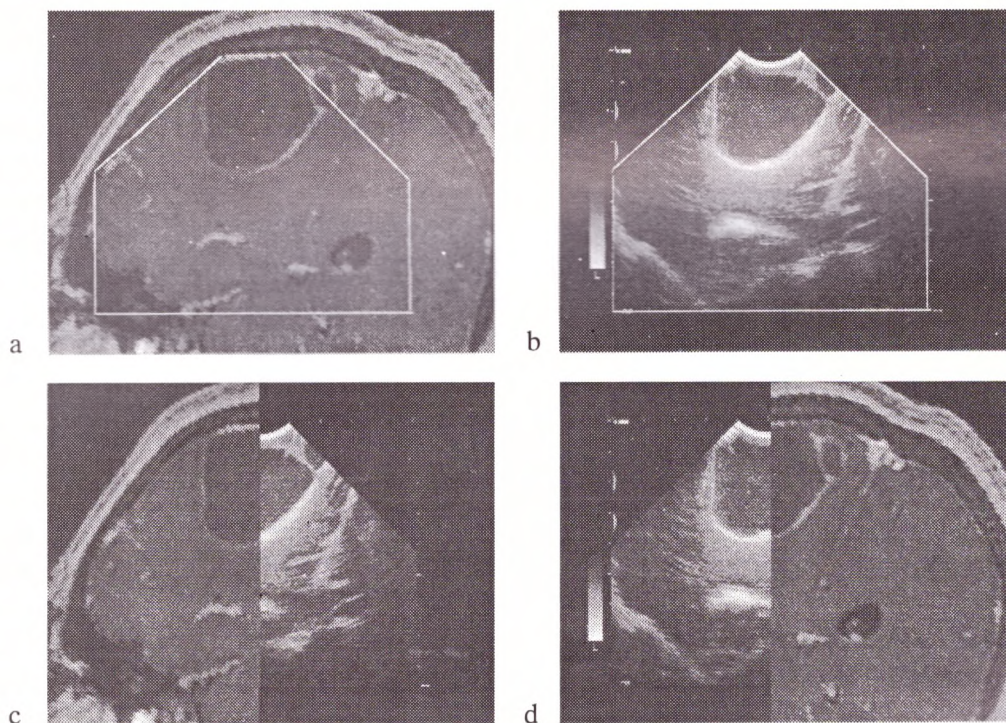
Corresponding intraoperative ultrasound (b, c, d) and reformatted MRI (a, c, d) images in a case of resection of a cystic metastatic tumor.
